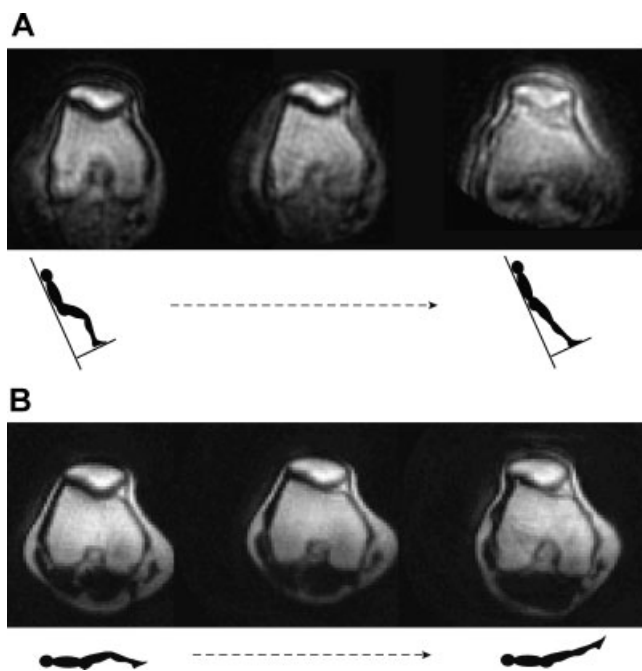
Oblique-axial real-time MR images through the patellofemoral joint during upright, weight-bearing knee extension (A) and supine, non-weight-bearing knee extension (B) in a maltracker from 30° of knee flexion to full extension.
